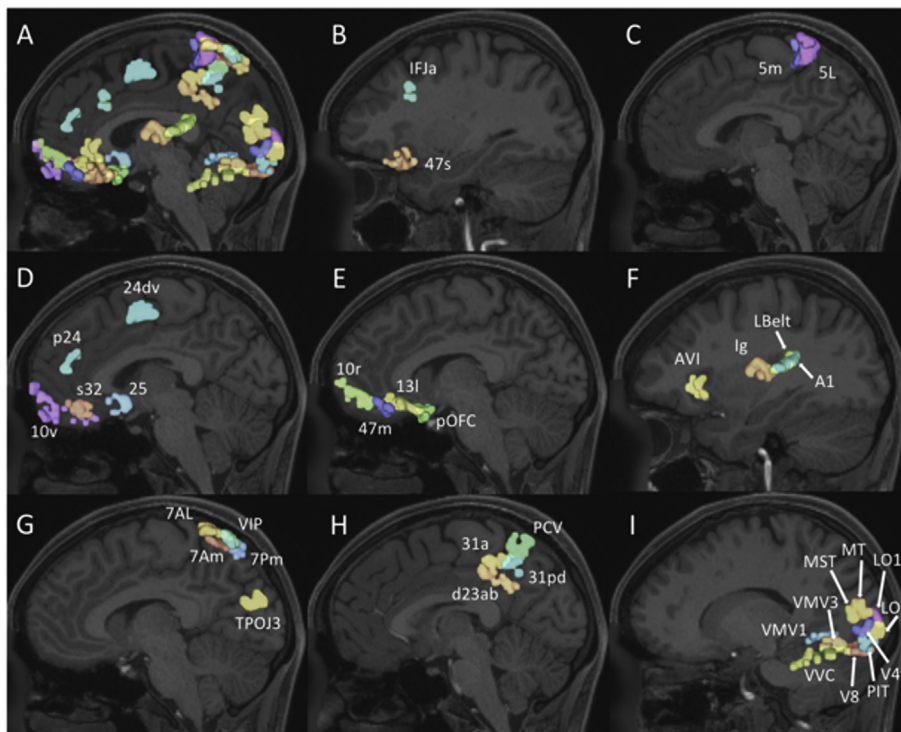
Cortical distribution of all thirty-six regions defined as having low average strength. These regions are plotted on sagittal T1-weighted images using a representative subject brain derived from the Human Connectome Project database. (A) All low strength regions are shown unlabeled. (B–I) Low strength regions are labeled on sagittal MRI cross-sections and organized into clusters: lateral frontal lobe cluster (B), paracentral lobule cluster (C), medial frontal lobe and cingulate cluster (D), orbitofrontal cluster (E), insula and superior temporal lobe cluster (F), superior parietal lobule cluster (G), precuneus cluster (H), and an occipital lobe cluster (I).
